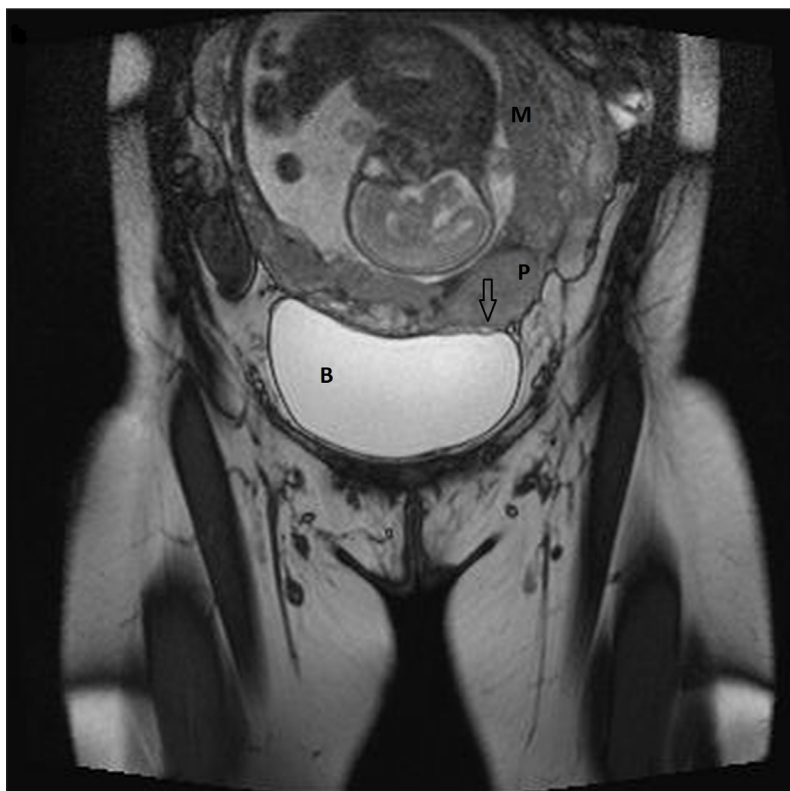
Coronal T2-weighted MR images. The upper wall of the bladder (B) is locally deformed from the left to 35 mm in length, contact and pressing (arrow) from the side of the placenta (P) is visible, in some places the wall contour of the bladder of the normal signal is clearly differentiated and hypervascular, inadequate myometrium (M)
